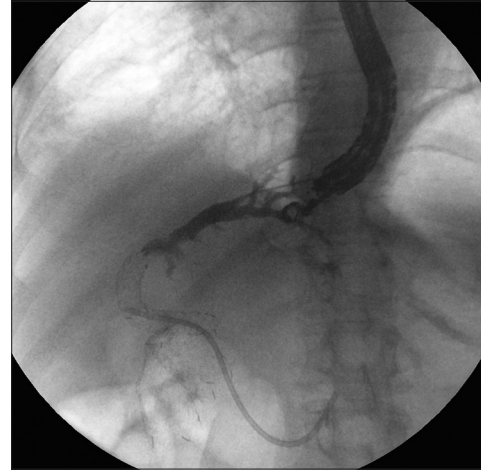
After deployment of a duodenal stent, access into the biliary tree was confirmed with an endoscopic ultrasound cholangiogram through the left lobe of the liver. Note that the plastic stent has migrated distally
